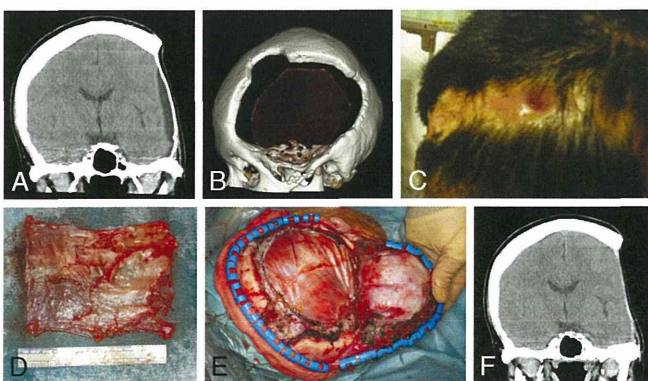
A, Preoperative CT scan shows a low-density area between the scalp and artificial dura mater. B, Three-dimensional CT scan demonstrates extensive cranial bone loss. C, A cutaneous fistula appeared on the scar. D, A free fascia lata graft measuring 10 × 12 cm in size harvested from the patient’s left thigh. E, The dural defect was closed using the fascia lata in a watertight fashion. F, Postoperative CT scan shows the reconstructed dura mater with the fascia lata in addition to the disappearance of the low-density area.
